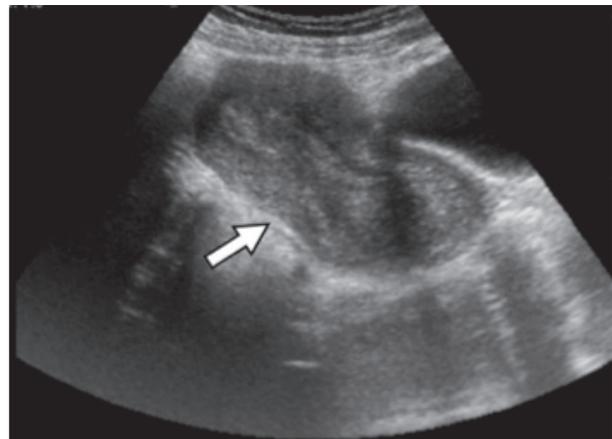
Transabdominal Ultrasound Showing the Typical Hour-Glass Configuration of the Uterus
